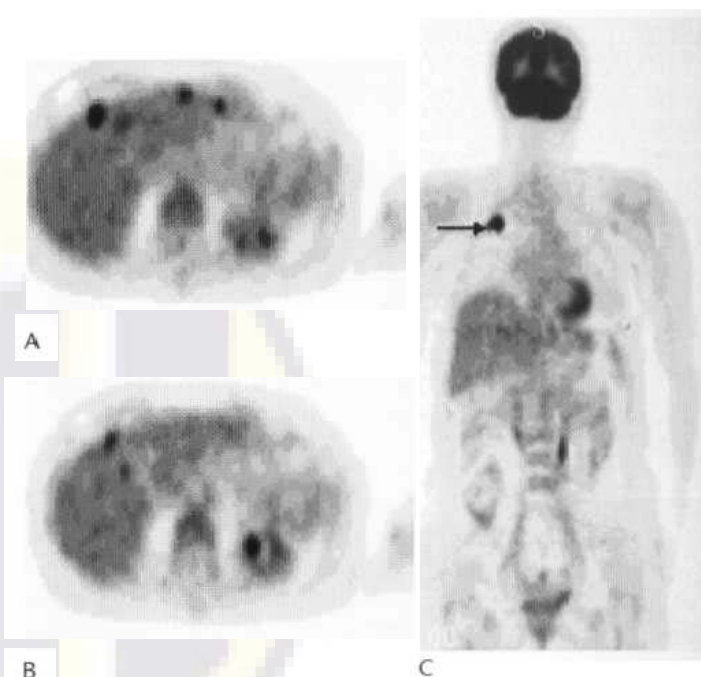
FDG-PET images in two patients with small-volume colorectal metastases, in the liver (A,B) and in the lung (C). (Courtesy of Professor P. J. Ell, Institute of Nuclear Medicine, Middlesex Hospital, London.)
